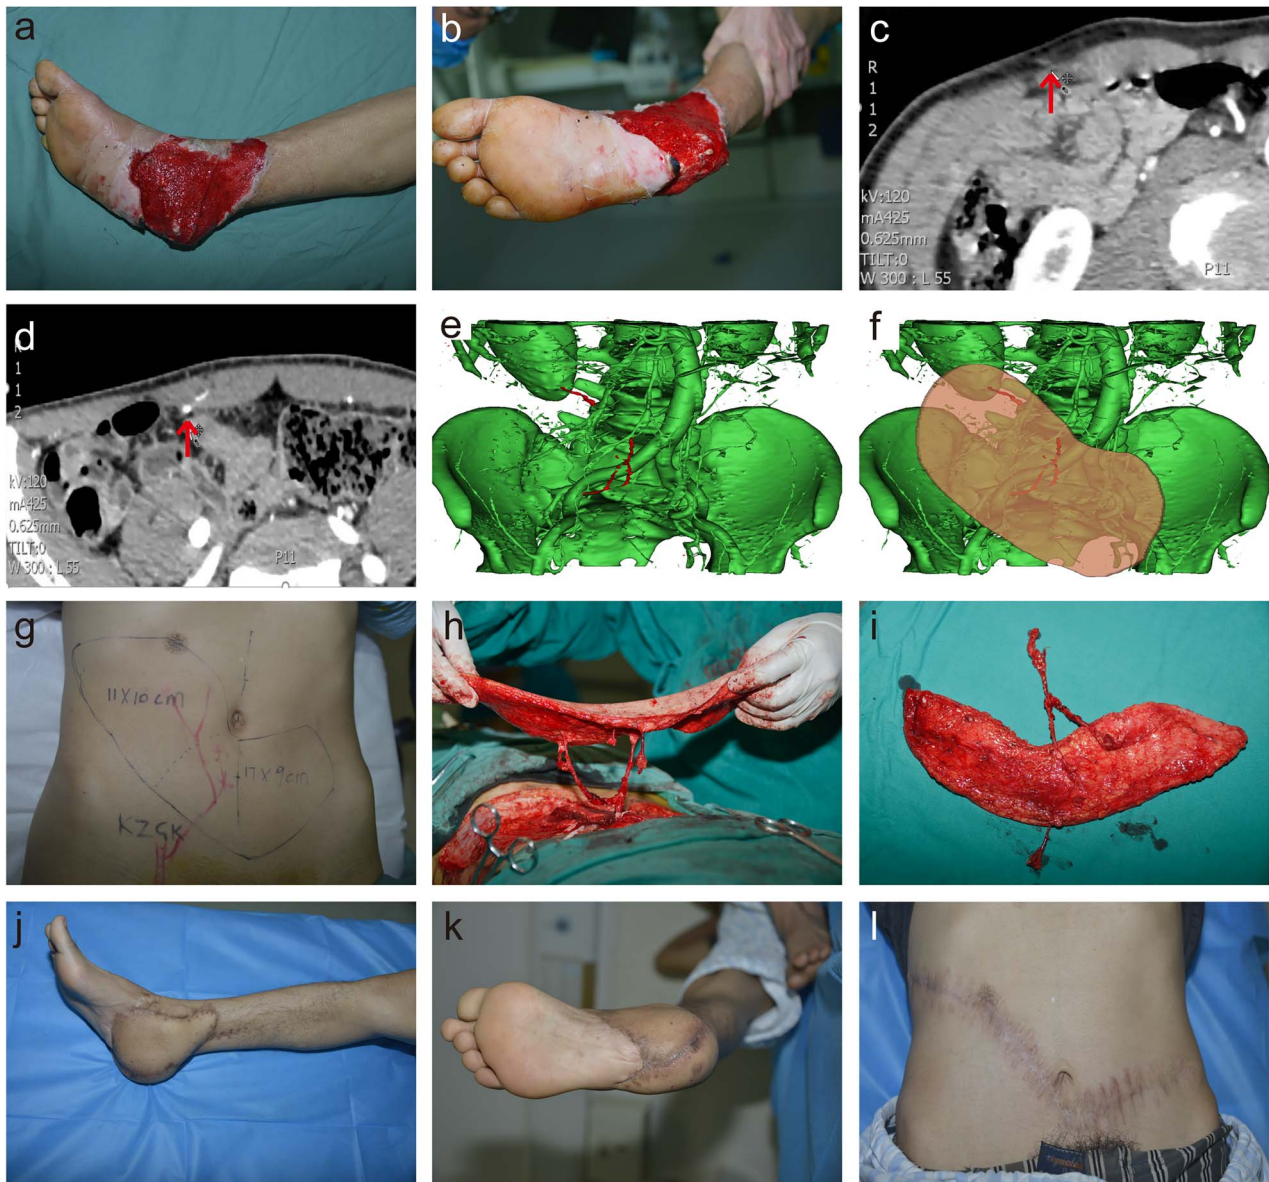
A double-paddle deep inferior epigastric perforator flap was utilized for reconstructing the soft tissue defect in the heel based on CTA. (a) Preoperative medial view of the defect. (b) Preoperative plantar view of the defect. (c) First perforator (the arrow) of the ipsilateral deep inferior epigastric artery on CTA. (d) Second perforator (the arrow) on CTA. (e) 3D model reconstructed based on the abdominal CTA images, with two red blood vessels showing ipsilateral deep inferior epigastric artery perforators. (f) Deep inferior epigastric perforator flap designed as a 3D model according to the defect size and perforator location. (g) Double-paddle flap designed based on CTA. (h) Harvesting of the flap during surgery based on preoperative planning. (i) Harvested double-paddle flap. (j) Postoperative medial view, 1 year after surgery. (k) Postoperative plantar view. (l) Postoperative donor-site view
